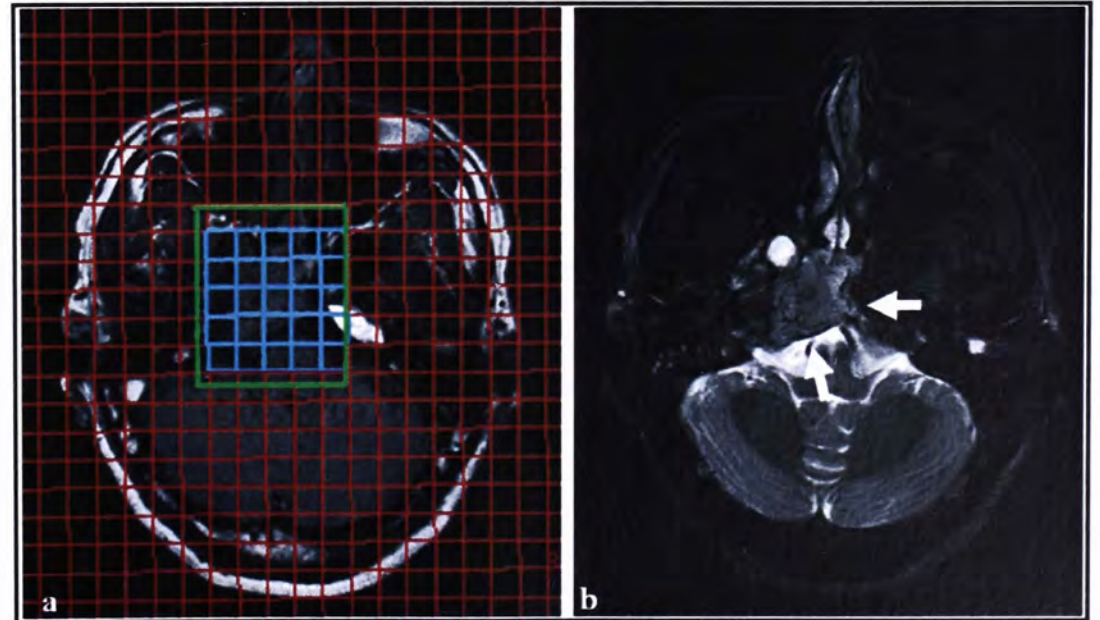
MRI images of a 53-year-old patient with NPC (subject 12).
